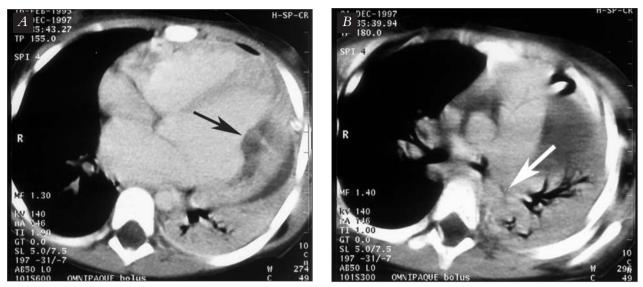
(A) Contrasted spiral CT scan of the heart: large flat thrombus (arrow) attached to the posterior wall of the left ventricle. (B) Left lung atelectasis owing to the compression of the left main bronchus (arrow)
